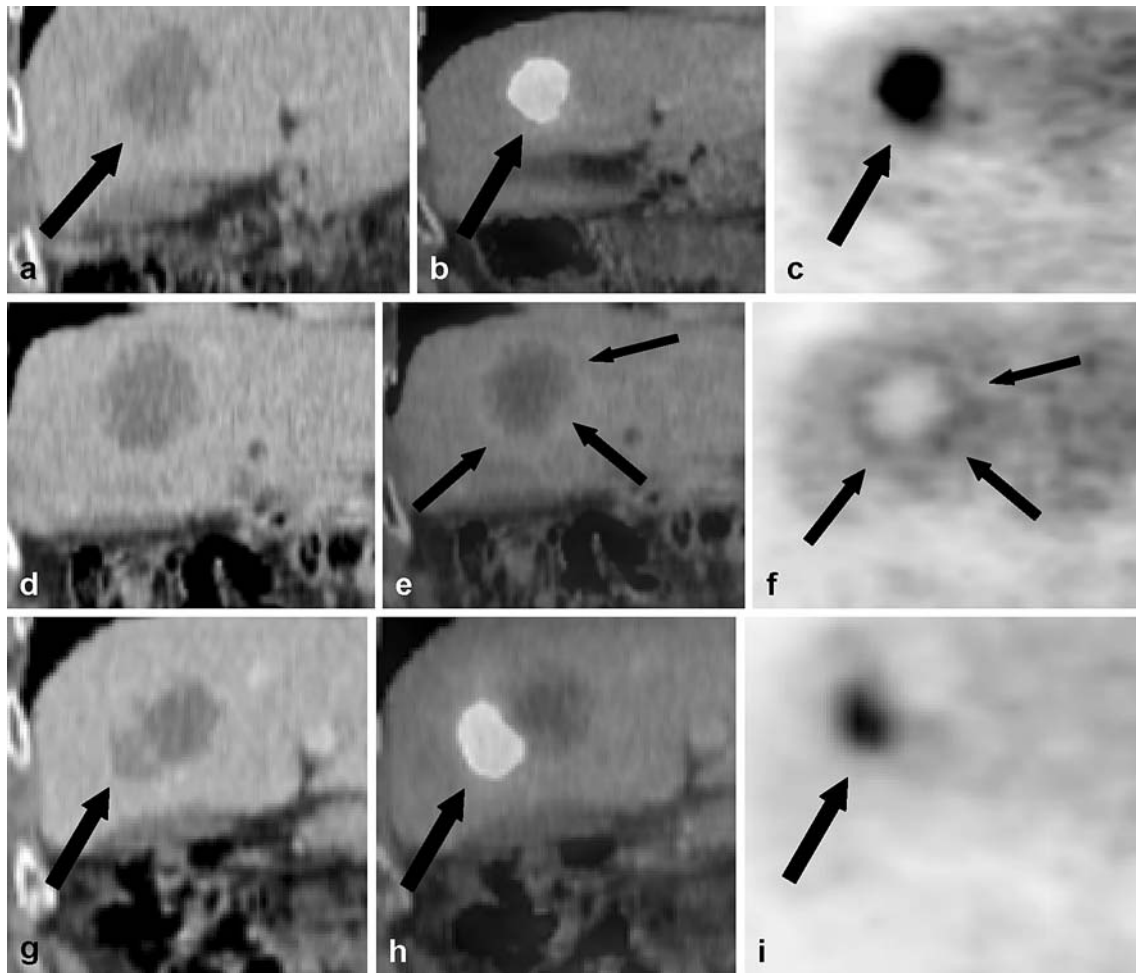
a Axial contrast-enhanced computed tomography (CT) image 90 days after a radiofrequency ablation (RFA) procedure in the right liver lobe: no evidence of local tumor recurrence. b Corresponding axial positron emission tomography PET/CT image (red scale): no evidence of local tumor recurrence. c Corresponding axial PET image (red scale): no evidence of local tumor recurrence. d Axial contrast-enhanced CT image 230 days after the RFA procedure in the right
